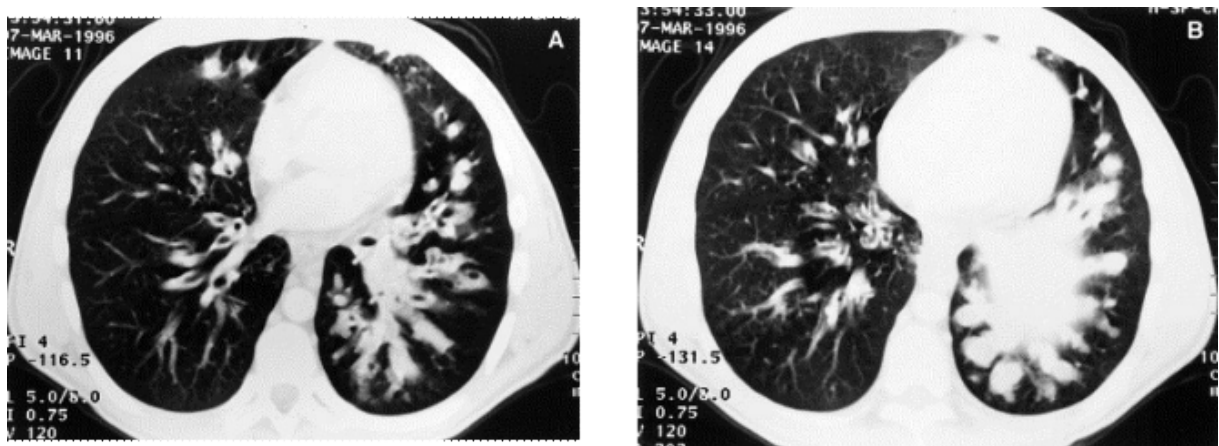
CT shows the presence of acute bronchiectasis and modest airway wall-thickening. In the left lung, extensive mucoïd impaction can be seen [33].
